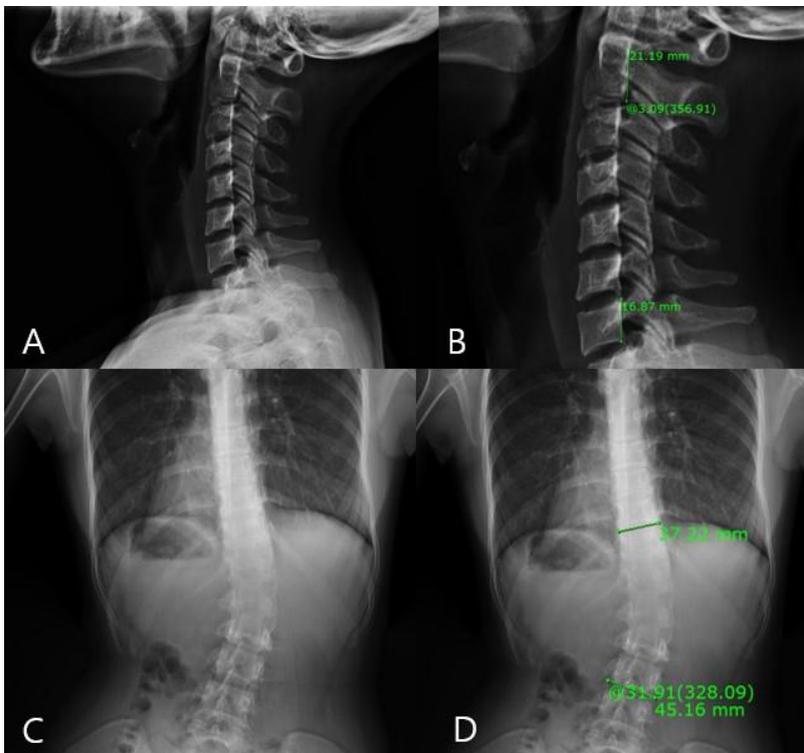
Cervical and thoracolumbar spine X-rays of a patient with cervical hypo-lordosis, also showing scoliosis. The Harrison posterior tangent angle and Cobb's angle are depicted in (B) and (D), respectively.
